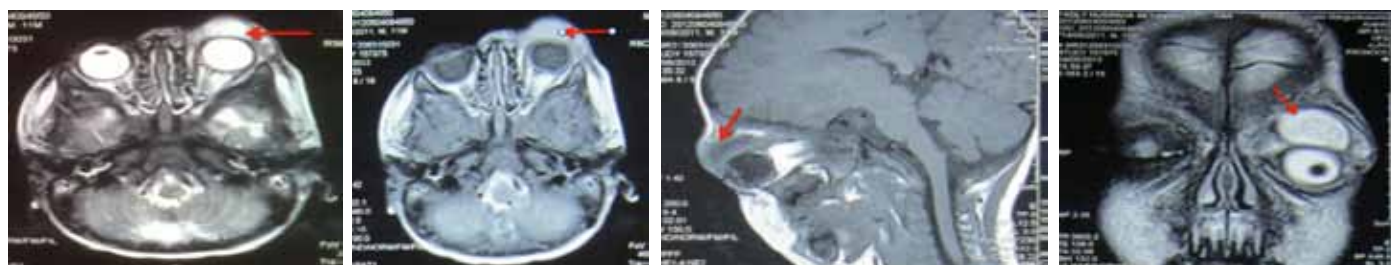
(a,b): Orbital MRI showing inflammatory lesion with abscess at the left superior eyelid. (c): Extension of inflammation to the orbital cavity, edema of intra-orbital fat tissue and left lacrimal gland. (d): The abscess was displacing globe infero-anteriorly.
